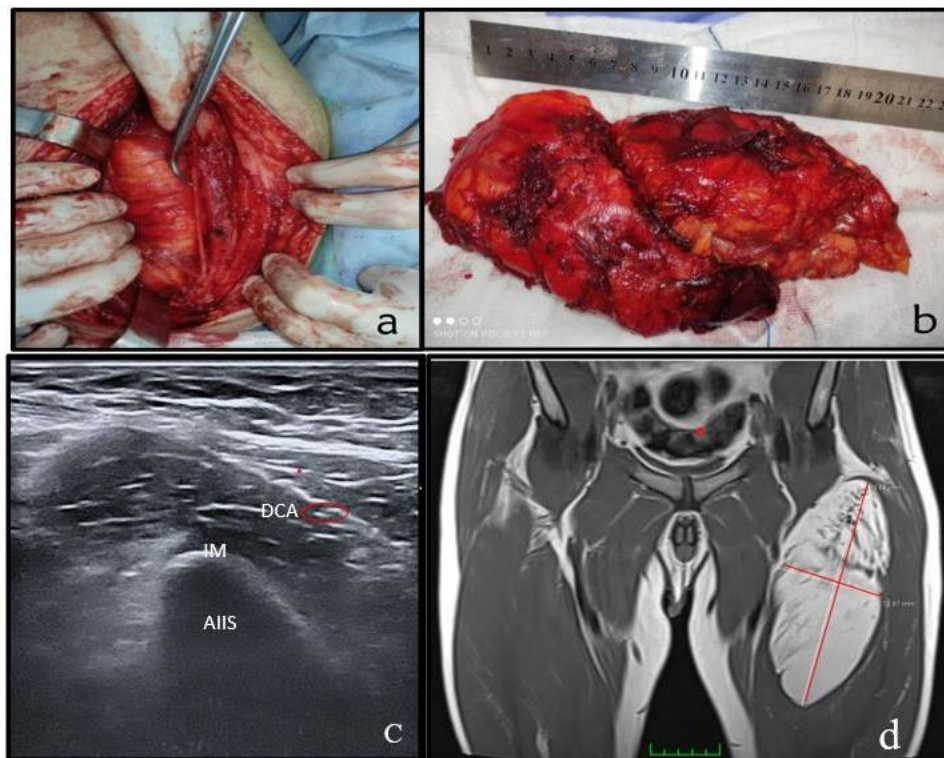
(a) Anterior 2/3 of the femur intraoperative surgical area; (b) Excised mass; (c) Sonoanatomical image; (d) MRI image of the mass.
